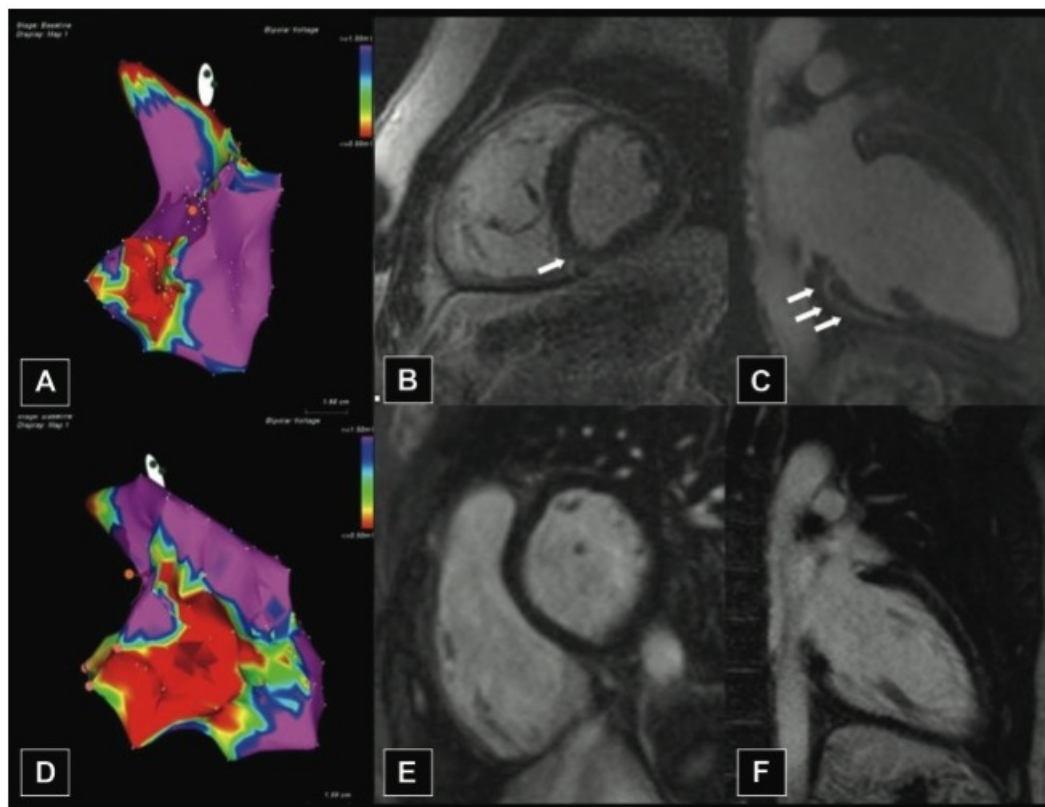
Representative cases of discordance between endocardial voltage mapping (EVM) and contrast-enhanced magnetic resonance (DE-MRI). A, Lateral view of the right ventricular (RV) EVM showing electroanatomical scar (EAS) in the RV inferobasal region and outflow tract. B and C, Basal short- and long-axis views of DE-MRI sequences showing no signs of delayed contrast enhancement (DE) in the RV free wall. Subepicardial DE is visible in the inferior and inferoseptal regions of the left ventricle (LV; white arrows). D, Lateral view of EVM showing a large EAS affecting the inferobasal, anterolateral, and, partly, RV outflow tract region. E and F, Basal short- and long-axis views of DE MRI showing neither RV nor LV DE. (From Martina Perazzolo Marra, MD, PhD et al "Imaging Study of Ventricular Scar in Arrhythmogenic Right Ventricular Cardiomyopathy / Clinical Perspective : Comparison of 3D Standard Electroanatomical Voltage Mapping and Contrast-Enhanced Cardiac Magnetic Resonance" *Circulation: Arrhythmia and Electrophysiology*. 2012; 5: 91-100, With Permission)
